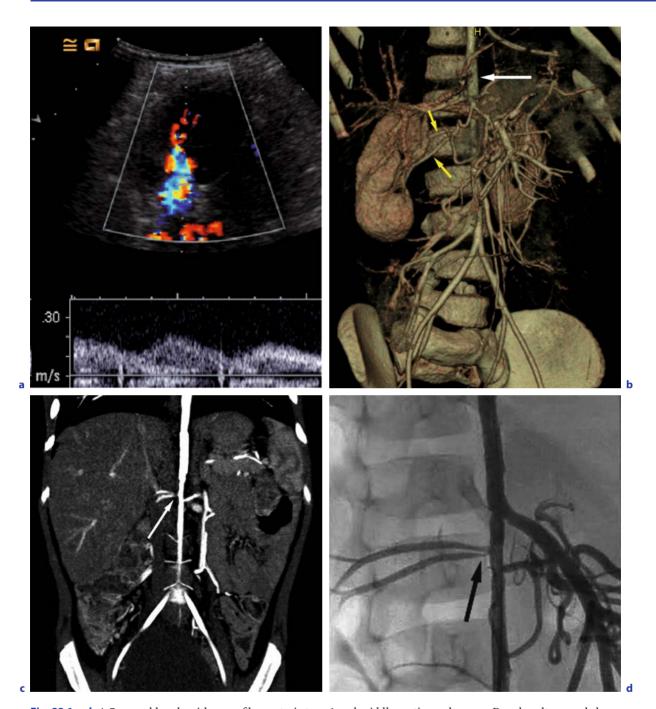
A 7-year-old male with neurofibromatosis type 1 and middle aortic syndrome. a Doppler ultrasound shows a "tardus et parvus" pattern with prolonged acceleration time and low velocity systolic peak in an artery at the right renal hilum. This was also present on the left side, suggesting aortic and/or bilateral renal artery stenosis. b Volume-rendered CT image shows an aortic stent (*large arrow*). There are two arteries to the right kidney (*small arrows*). c Coronal reformatted CT image shows that these two arteries have a common origin, which may be narrow (*arrow*). d Aortography confirms that the right renal arteries have a common origin (*arrow*) and shows that both have mild focal stenoses
